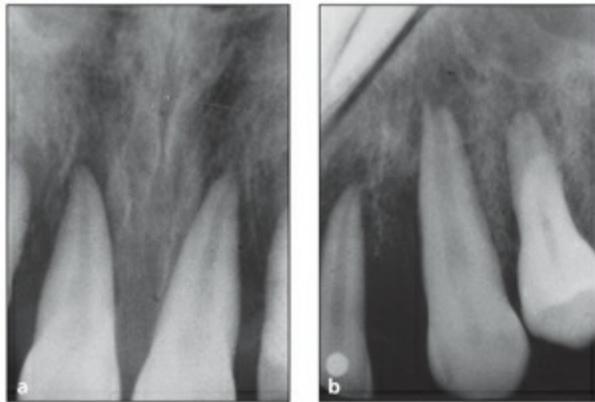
(*a and b*) Periradicular radiographs of a 13-year-old patient with acute monocytic leukemia. Note the uniform widening of the periodontal ligament space.
